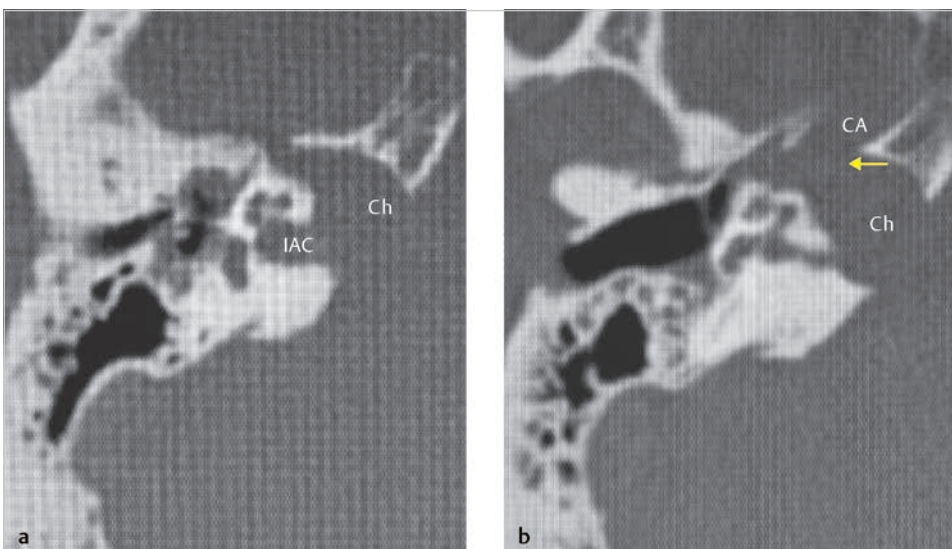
The axial CT (a) shows presence of soft tissue density in the petrous apex eroding the internal auditory canal from inferior (a). The posteroinferior face of the carotid canal is also eroded (b) (arrow). Ch, cholesteatoma; CA, carotid artery; IAC, internal auditory canal.
